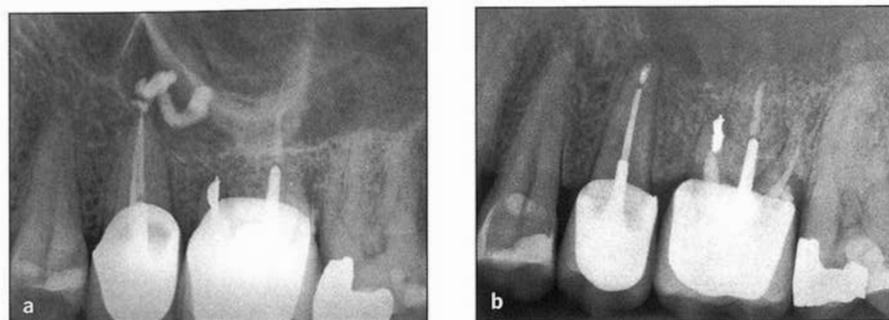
(a) Preoperative radiograph of a maxillary second premolar with an overfill into the maxillary sinus. (b) Postoperative radiograph after surgery to remove the overfill and placement of MTA as a root-end filling material.
